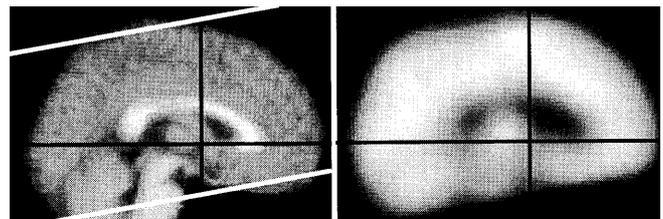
The rostrocaudal extent of the regions of the brain from which regional cerebral blood flow data was acquired. The *left image* is the mean normalized MR image of our 24 subjects. The *right image* is the mean normalized PET image of the same subjects. The approximate boundary of the PET data set is marked on the MR image
